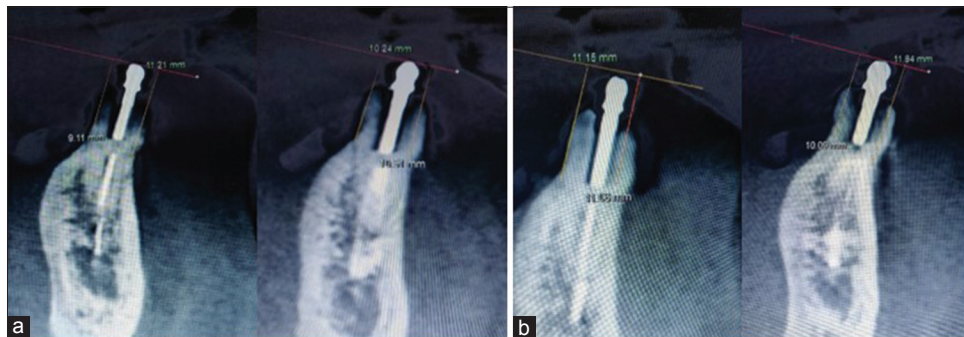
(a) Pretreatment cone-beam computed tomography taken just prior to the denture insertion. (b) Posttreatment cone-beam computed tomography taken 12 months after the denture insertion (Pre-fabricated access post)
